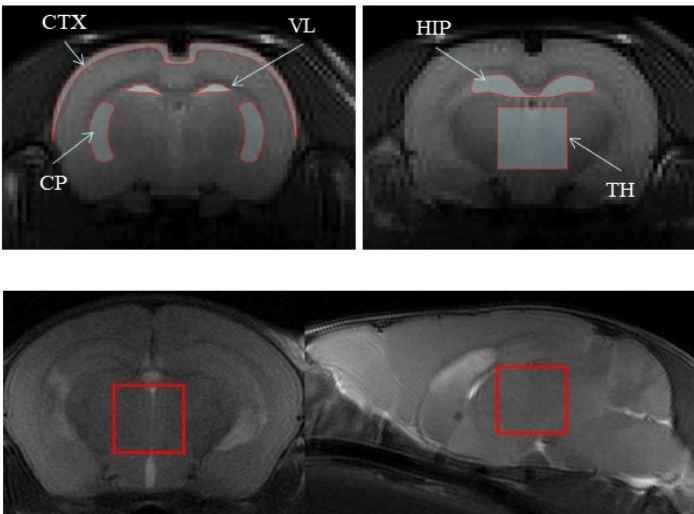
1 The anatomic structures were identified in T2-weighted images, including the cerebral cortex (CTX), hippocampus (HIP) and thalamus (TH), caudoputamen (CP), lateral ventricle (VL). The red outlines indicate the regions-of-interest used for measurements. In the bottom images, the dimensions of the MRS experiment within the thalamus are shown in the rectangular box in both the coronal and sagittal plane. The area of the thalamus region-of-interest for CEST measures was within the area where MRS was measured.
